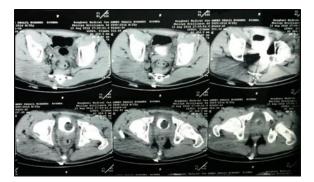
CT scan with contrast in which the extravasation of contrast cannot prove because of the overlaps of the contrast shadow and the effects of CT scan radiation on the metallic material of bullet.
